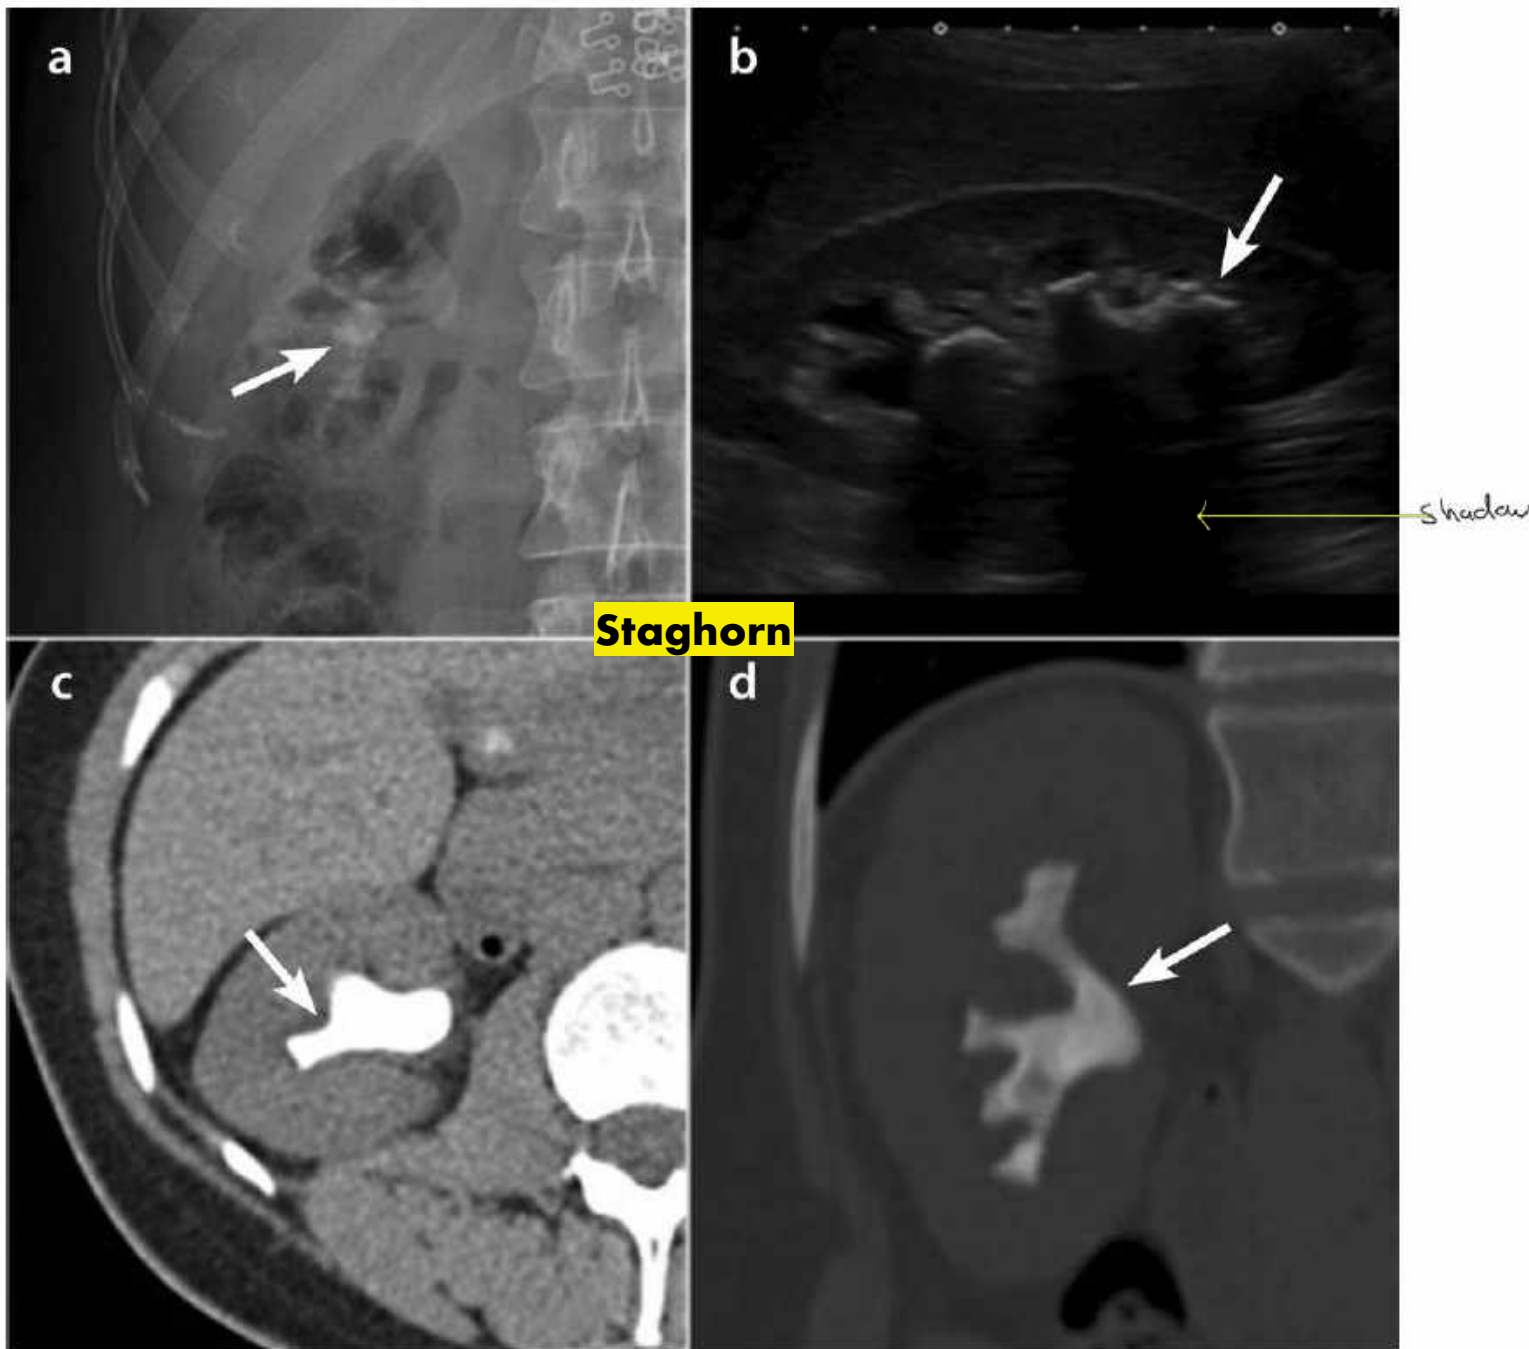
A large right staghorn calculus is somewhat obscured by bowel gas on a plain abdominal X-ray (a). It is clearly seen on longitudinal ultrasound (b) with classical posterior acoustic shadowing and mild dilatation of the upper pole calyx. The staghorn calculus is clearly seen on axial non-contrast computed tomography (c) and coronal reconstruction (d).
